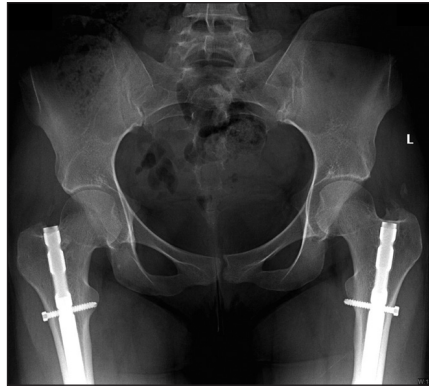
Preoperative anteroposterior radiograph of Patient 3 showing bilateral femoral nails, coxa profunda, pincer-type femoroacetabular impingement, and no evidence of arthritis or avascular necrosis.
